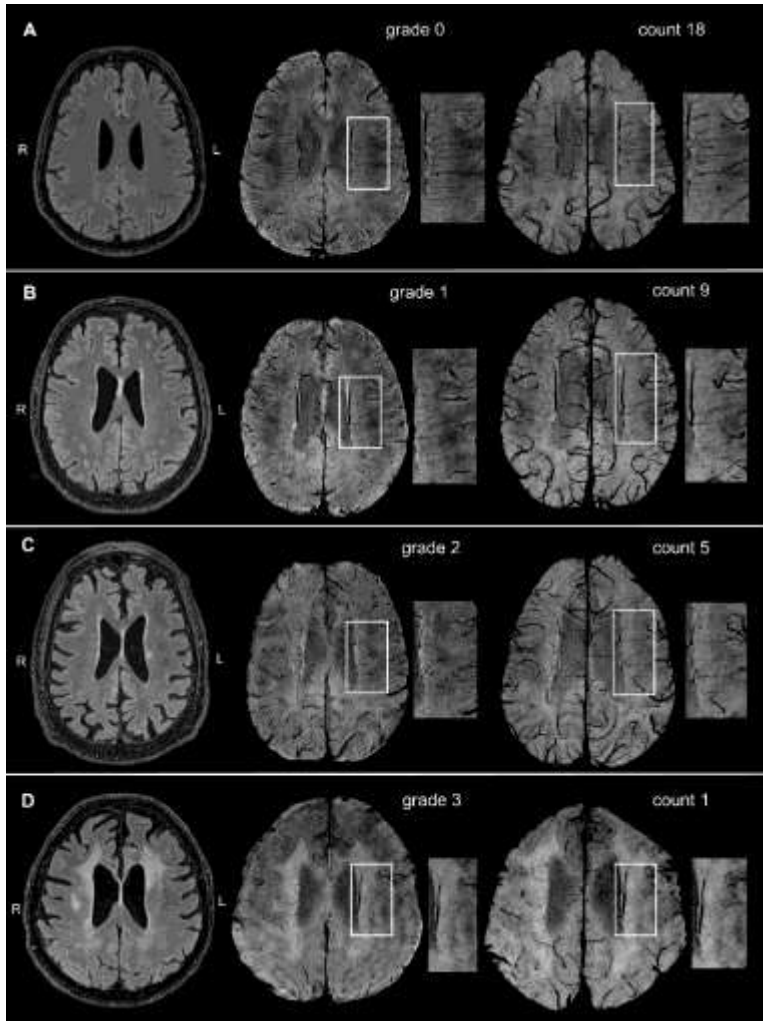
Examples of DMV assessment methods. The left column shows the different degrees of SVD on FLAIR sequences; the middle column represents the appearance-DMV score on SWI sequences, the right column represents the corresponding count in the left hemisphere on MIP sequences. (A) Male, 64 years. There are no visible signs of WMH on FLAIR, on SWI each vein is continuous and has quite a homogeneous signal (grade 0) and on MIP a total of 18 veins can be counted. (B) Male, 74 years. No visible signs of SVD on FLAIR sequence, each vein is continuous but at least there is one with inhomogeneous signal (grade 1) and we count 9 veins in the left hemisphere. (C) Male, 84 years. There are some non-confluent WMH on FLAIR (Fazekas grade 1), at least one vein is not continuous with a spot-like hypointensity (grade 2), while the total number of veins is 5. (D) Male, 70 years. There are large confluent WMH, none of the veins are continuous (grade 3) on SWI and only one vein can be counted on MIP.
